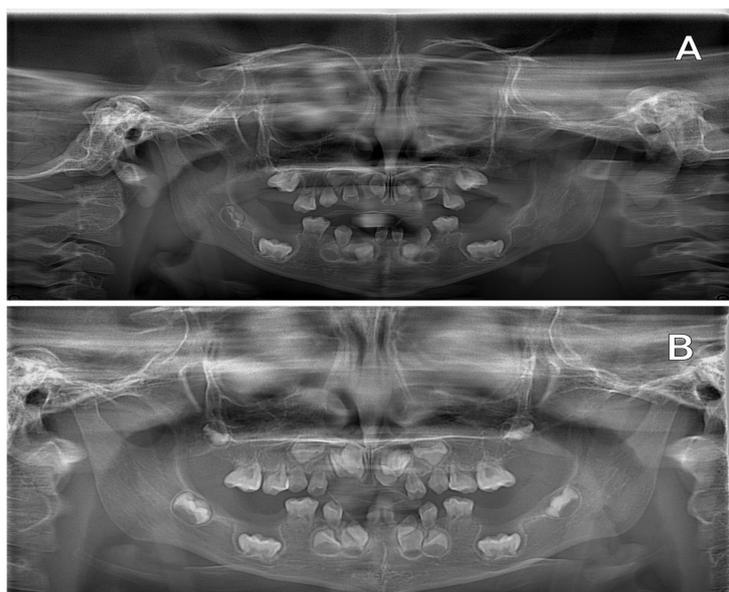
(A) The panoramic radiograph taken when the patient was 50 months old, (B) 63 months old.
